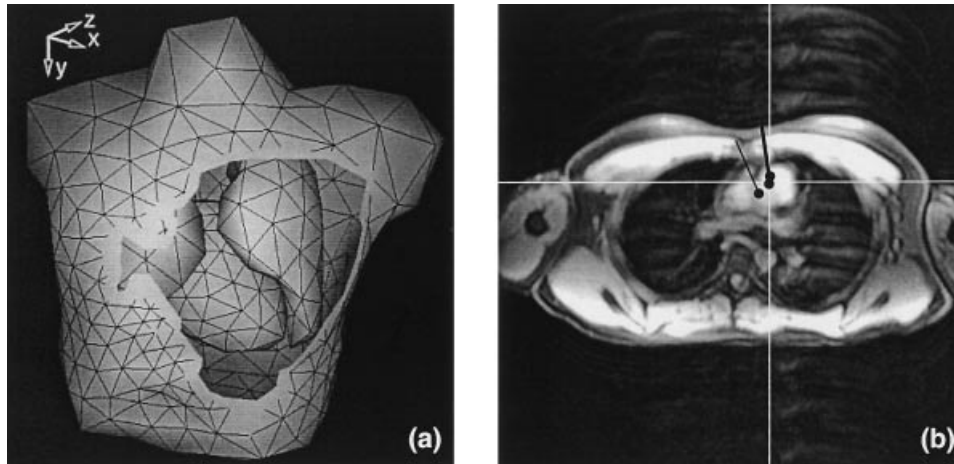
(a) An example of a boundary-element torso model constructed from MRI data. The surfaces of the body, the lungs, and the heart are tessellated into triangulated networks. The total number of triangles here is about 1500. (b) An example of MCG localization of tachycardias. The patient was suffering from continuous atrial tachycardia with the heart rate of over 140 beats per minute. ECD localization was performed from 67-channel MCG data at the onset of the P-wave, and the ECD locations were superimposed on the MRI data. Catheter ablation performed later at the location pinpointed by the MCG result terminated all arrhythmias.
